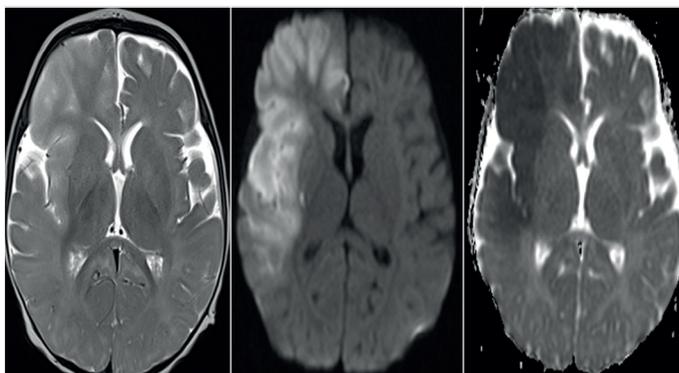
Acute infarction in the right MCA. T2-weighted image showing hyperintensity. DWI showing restricted diffusion and ADC map showing low signal, confirming restricted diffusion (Case 6).
